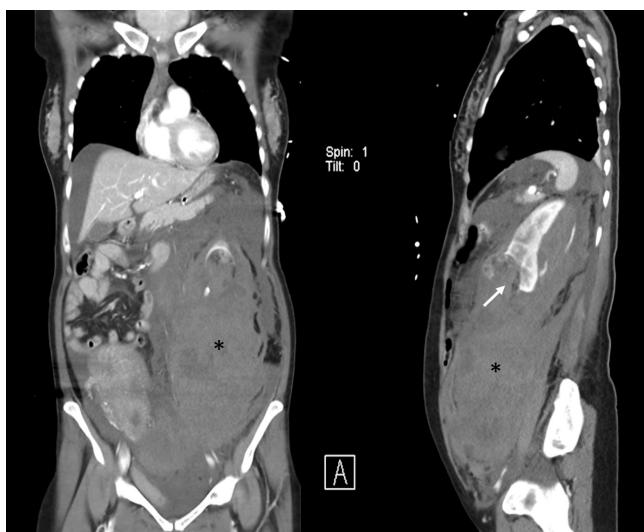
CTA Abdomen in portovenous phase (coronal and sagittal images) showing poor demarcation of the lower part of the lesion suggesting ruptured tumor (white arrow). Note the large left perinephric hematoma (*) displacing the bowels and mesentery to the right. The hematoma extends into the peritoneal cavity, particularly within the pelvic cavity
